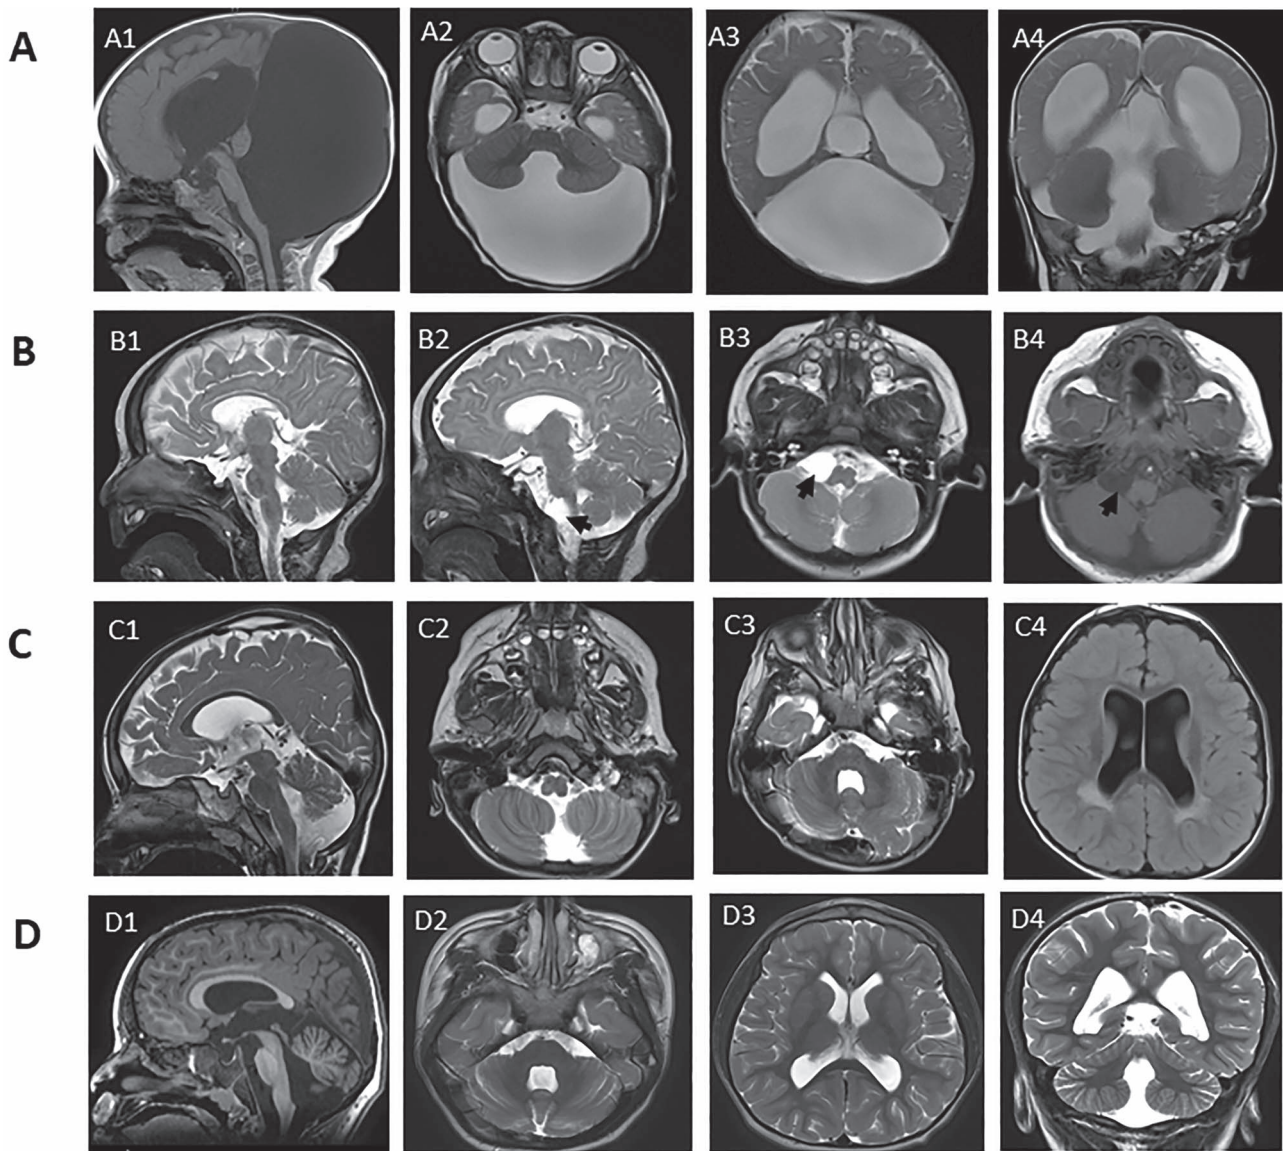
Cranial magnetic resonance images of four individuals with variable degrees of posterior fossa malformations. (A) Images of individual 2 at age 8 months; sagittal T1 (A1), axial T2 (A2 and A3) and coronal T2 (A4); showing cystic dilatation of the fourth ventricle extending posteriorly and directly communicating with a massively enlarged posterior fossa, with associated hypoplasia/dysgenesis of cerebellar vermis and small cerebellar hemispheres and cephalad rotation of the vermian remnant (Dandy–Walker malformation). In addition, significant supratentorial hydrocephalus with dilated lateral and third ventricles is seen causing stretching of the overlying corpus callosum. (B) Images of individual 3 at age 5 months; sagittal T2 (B1 and B2), axial T2 (B3) and axial T1 (B4); showing a well-defined right cerebellopontine angle cyst $1.2 \times 1.5 \times 1.5$ cm (arrow in B2, 3 and 4) and hypoplasia of the splenium of the corpus callosum (best seen in B1). (C) Images of individual 5 at age 3 years; sagittal T2 (C1), axial T2 (C2 and C3) and axial FLAIR (C4) show dilatation of the fourth ventricle that directly communicates with a mildly enlarged posterior fossa, with associated hypoplastic inferior cerebellar vermis. In addition, dilatation of lateral and third ventricles is seen, as well as periventricular white matter hyperintensity around the posterior horn of the lateral ventricle bilaterally (seen best in C4). (D) Images of individual 6 at age 6 years; sagittal T1 (D1), axial T2 (D2 and D3) and coronal T2 (D4) show dilatation of the fourth ventricle that directly communicates with a retrocerebellar cyst, with associated hypoplastic inferior vermis. In addition, dilatation of lateral and third ventricles is present.
